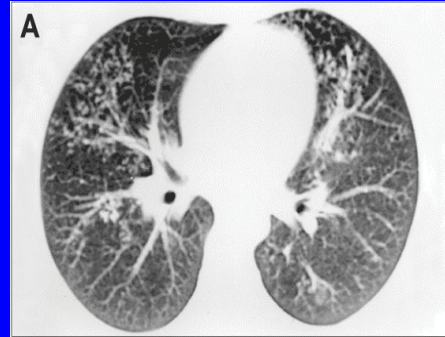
(A) Computed tomography at the start of treatment: central nodules with segmental distribution in the anterior parts of both lungs. (B) Computed tomography post-treatment, for the same patient: absence of the alterations observed at the start of treatment.
